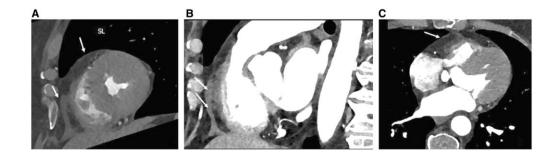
Cardiac computed tomography, multiplanar reconstructions (*A*) short-axis view; (*B*) right ventricular outflow tract view; (*C*) long-axis four-chamber view. Arrows indicate a small focal collection of pericardial fluid in the right ventricular outflow tract and right ventricular free wall. RV, right ventricle.
